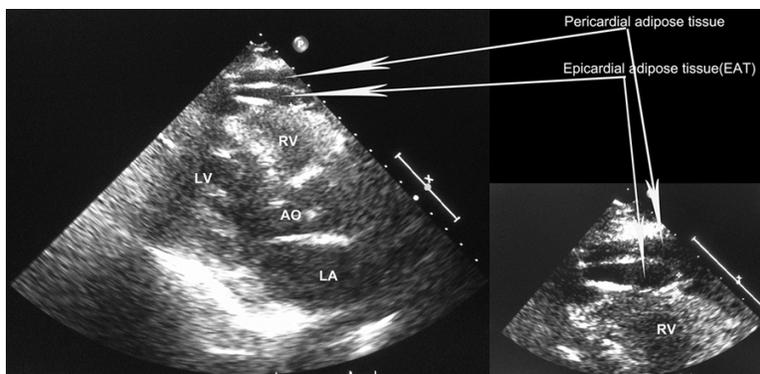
Transthoracic echocardiography image (parasternal long axis view) showing the measurement of epicardial adipose tissue thickness on the free wall of the right ventricle near the aortic annulus. AO: aorta; EAT: epicardial adipose tissue LA: left atrium; LV: left ventricle; RV: right ventricle.
